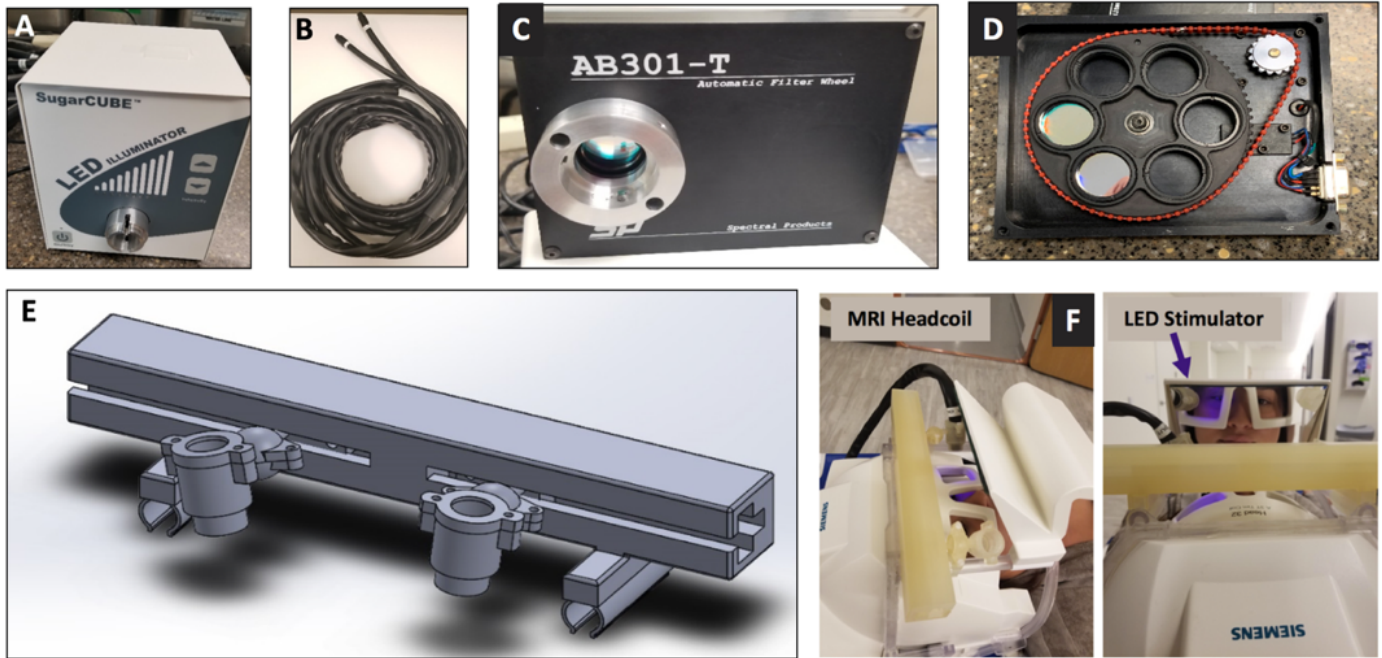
Our lab has constructed a unique fiber-optic LED stimulation system that allows direct unilateral or bilateral stimulation with various wavelengths during MRI scanning. This light stimulation system is built into the MRI head-coil and is designed to allow free viewing of projected stimuli and direct monitoring of pupillary response, eye-blink rate, and eye-tracking during functional MRI scanning.
